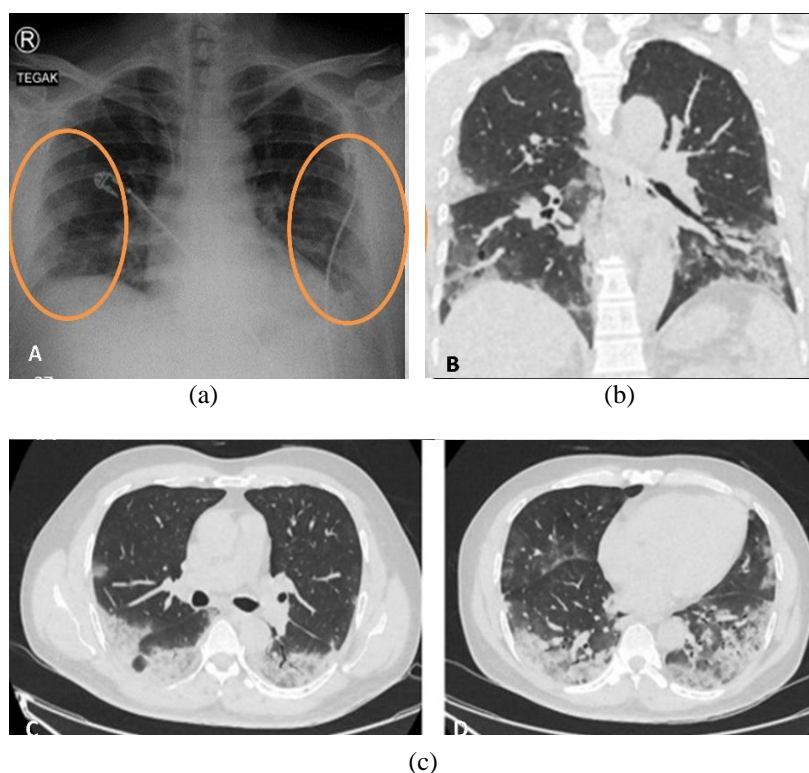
Radiological imaging of the male patient's chest: (a) X-ray, (b) coronal CT scan, and (c) axial CT scan
